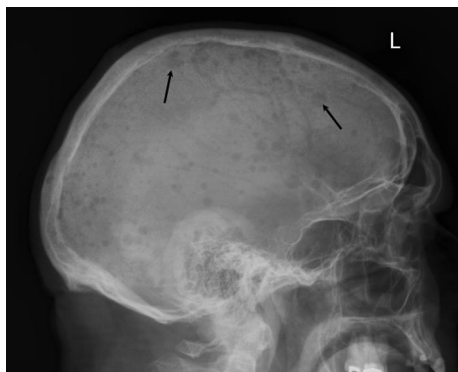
Lateral skull radiograph showing multiple well defined osteolytic lesions of varying sizes throughout the skull vault (arrows)
